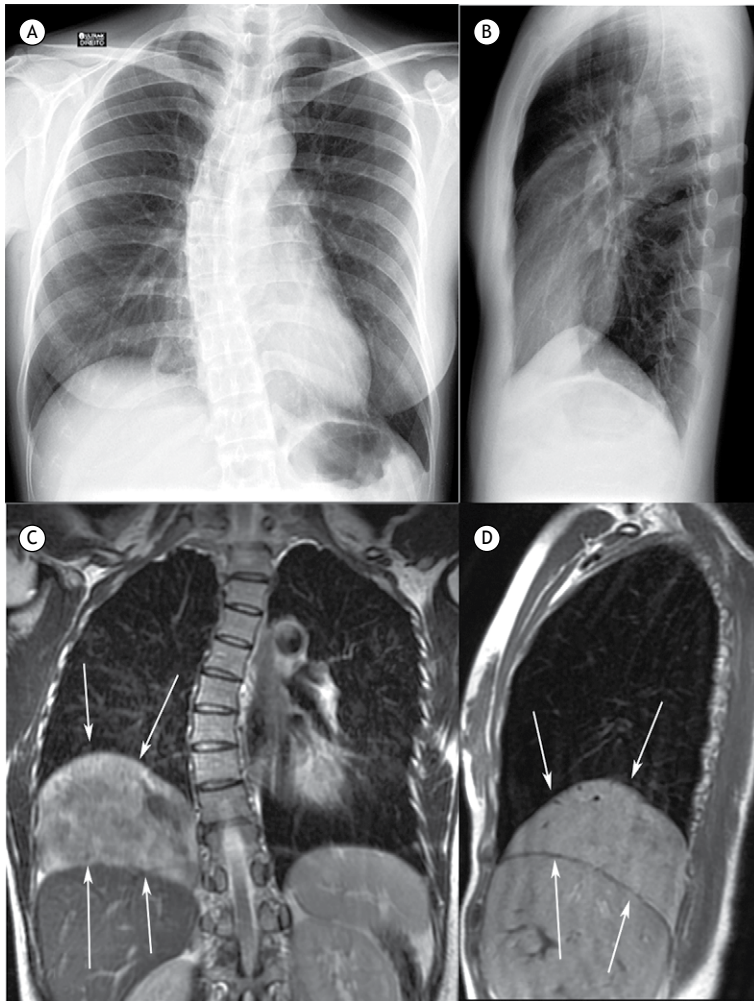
Frontal and lateral chest X-rays (A and B, respectively) showing elevation of the right lung base. Unenhanced coronal T2-weighted and sagittal T1-weighted magnetic resonance imaging scans (C and D, respectively) showing a large mass (arrows) occupying the inferior region of the right hemithorax with a heterogeneous, intermediate signal. The mass lies between the right lung base and the liver, with a well-defined cleavage plane between the two.
